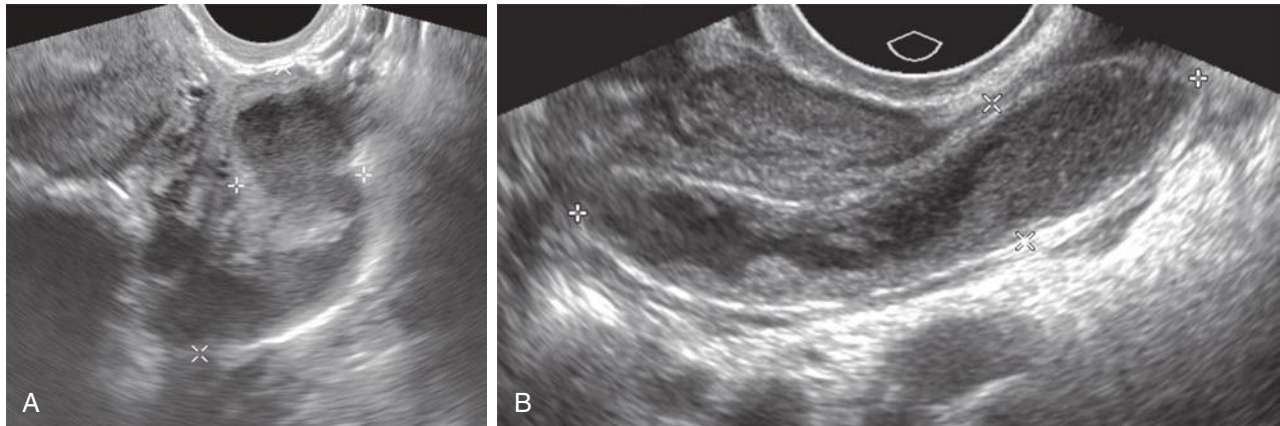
Pyosalpinx. A, Distended thick-walled fallopian tube (*calipers*) containing complex fluid compatible with pyosalpinx. B, Pitfall: acute appendicitis. Debris-filled tubular structure (*calipers*) in the right adnexa was initially thought to represent pyosalpinx. However, no endosalpingeal folds are identified and this is a blind-ending structure. Computed tomography scan (not shown) confirmed acute appendicitis.
